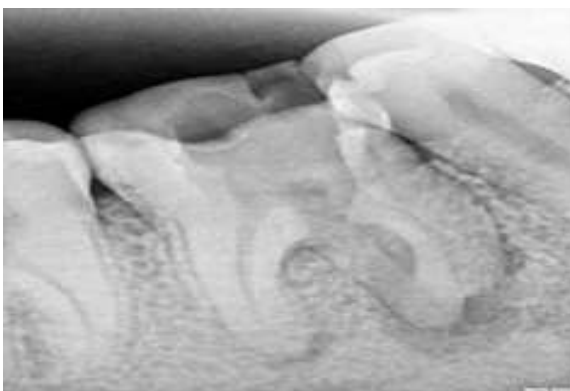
Pre-operative radiographic view
